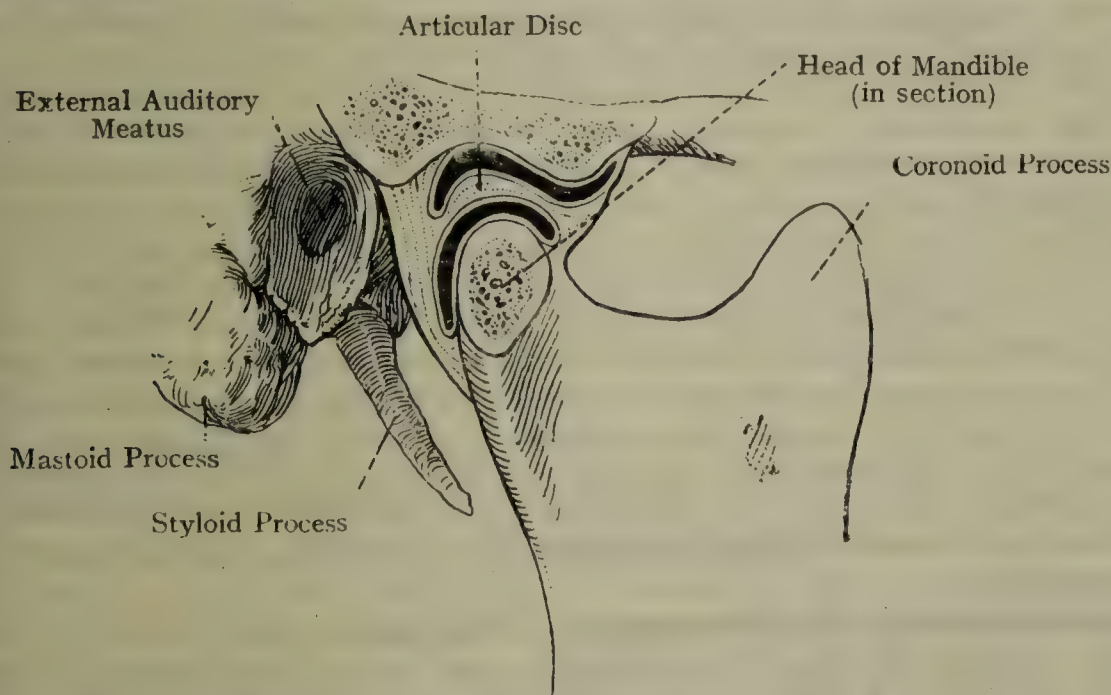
THE MANDIBULAR JOINT OPENED (LATERAL ASPECT).
